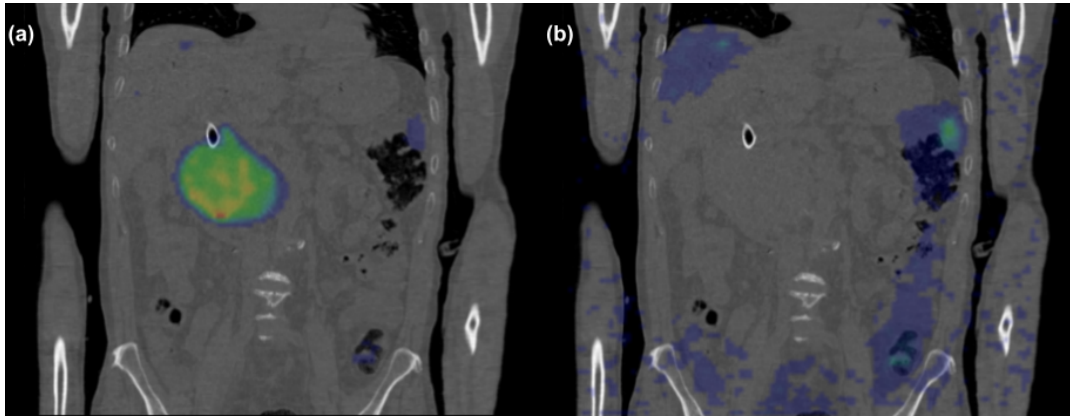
Superposition of the 24H SPECT image of cycle 1 including lesion and CT (a) and the 24H SPECT image of cycle 1 without lesion and CT (b) for patient 5 of the *patient cohort*.
